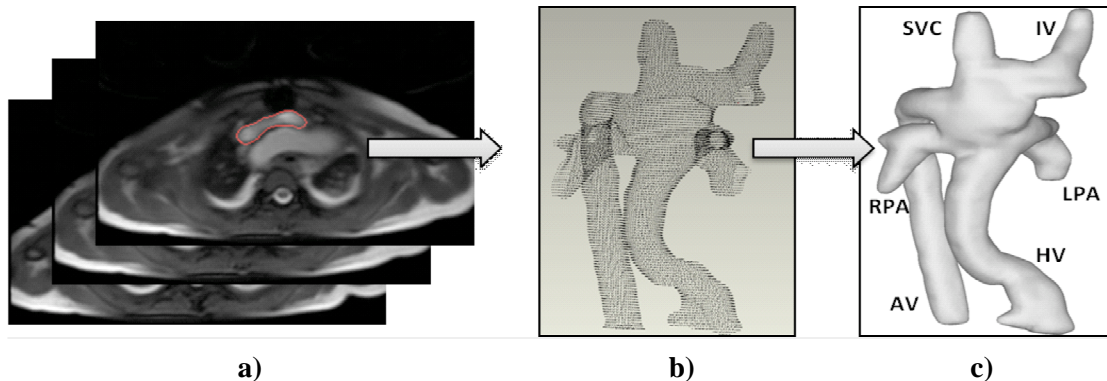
Steps for the anatomic reconstruction of the TCPC from the stack of axial MRI. a) The TCPC is first segmented in each slice; b) The segmented contours are then imported into Geomagic Studio 9.0 (Geomagic Inc., NC, USA); c) A smooth surface is fitted to the points to obtain a 3D anatomic reconstruction of the TCPC.
